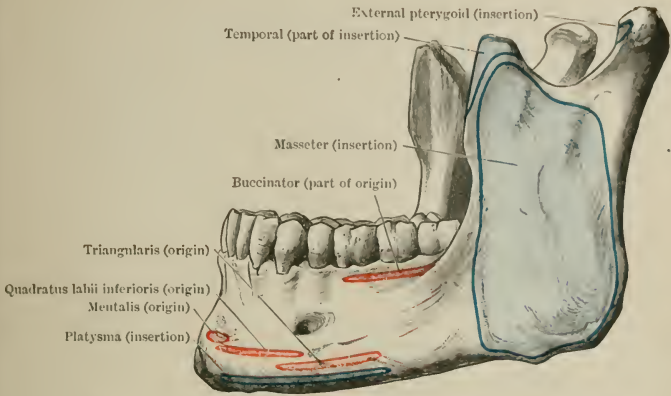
MUSCLE ATTACHMENTS TO THE LATERAL ASPECT OF THE LOWER JAW.
